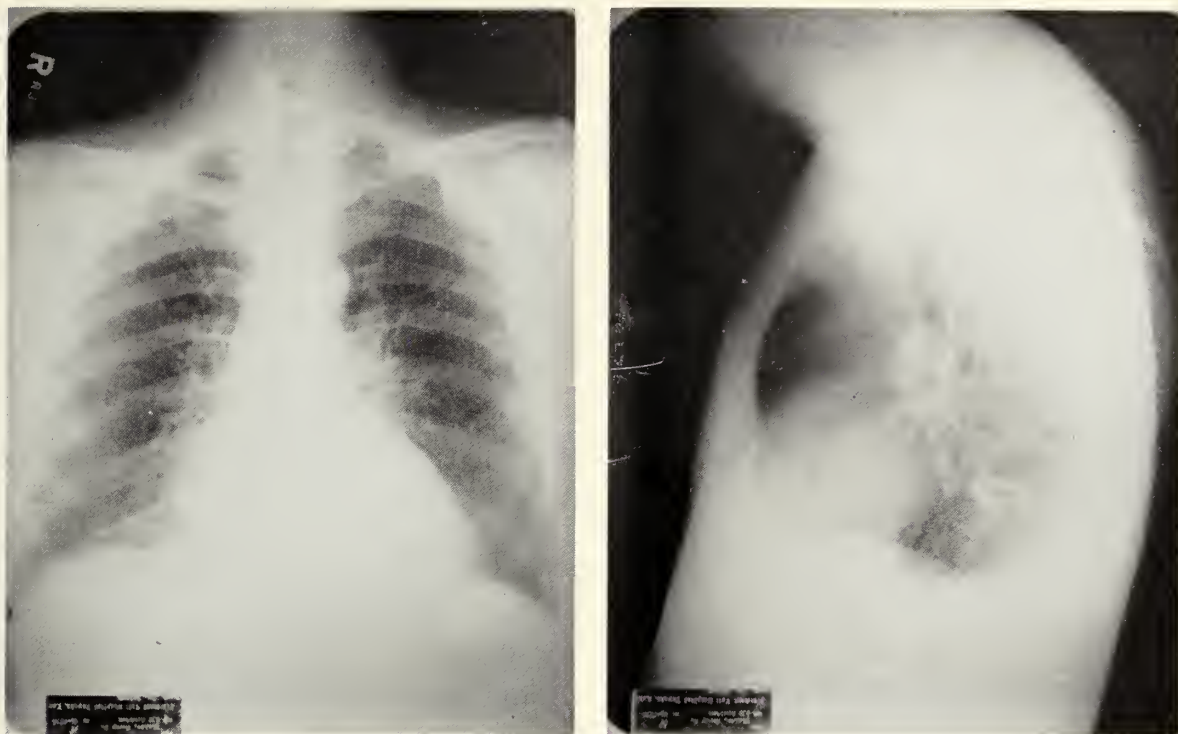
Chest x-rays showing cardiac enlargement. Lateral view shows a small effusion behind the dome of the diaphragm.
